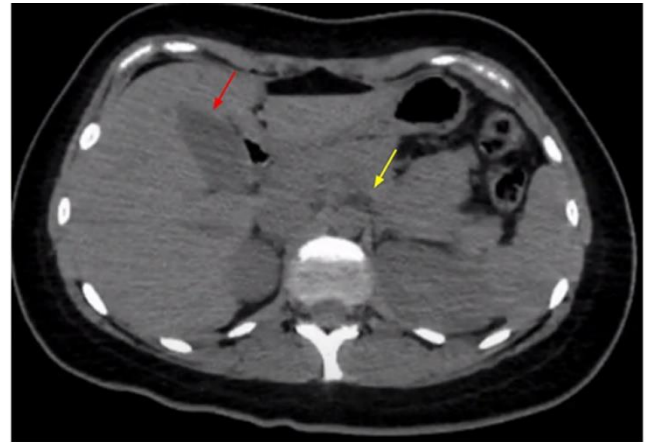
Abdominal CT scan without contrast from the abdomen showing gallbladder edema (red arrow) and pancreas body edema (yellow arrow); the head of the pancreas is difficult to see.
